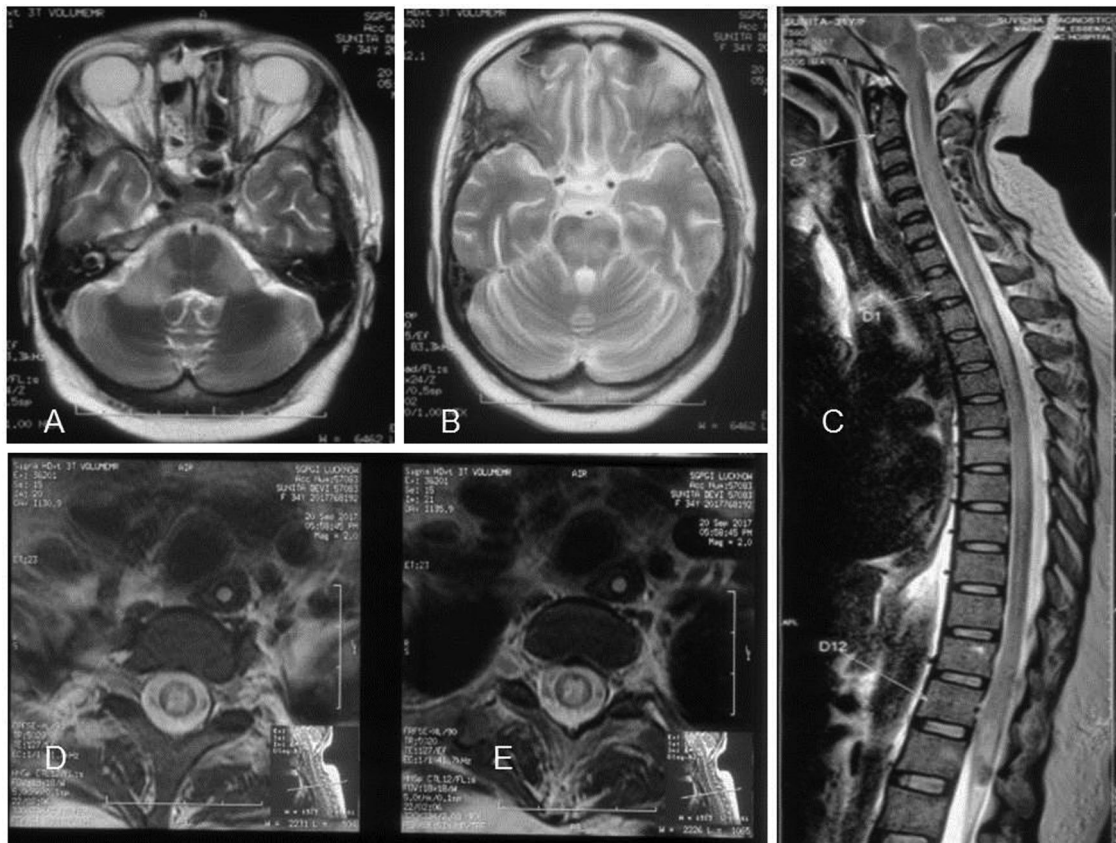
Cranio-spinal MRI in T2 sequence shows hyperintense signal changes in middle cerebellar peduncle bilaterally (A), central pons (B), whole of spinal cord (C). Axial sections of spinal cord (D & E) show hyper intense signal changes in the central part.
